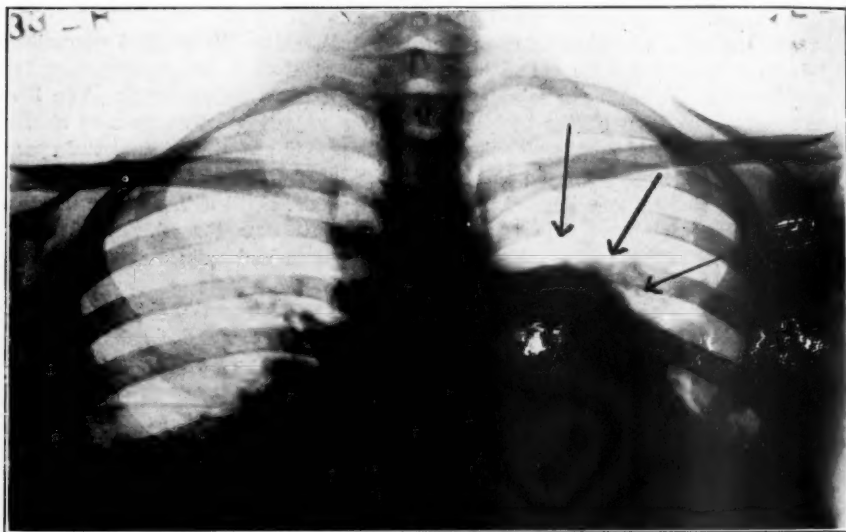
Roentgen-ray examination of the chest on admission to the Montefiore Hospital revealed a moderate amount of fluid in the right pleural cavity. The heart was enlarged and rotated so that the aortic knob was not visible in the anteroposterior position. There was an unusual dilatation of the pulmonic artery which formed the first curve on the left side of the heart shadow.
